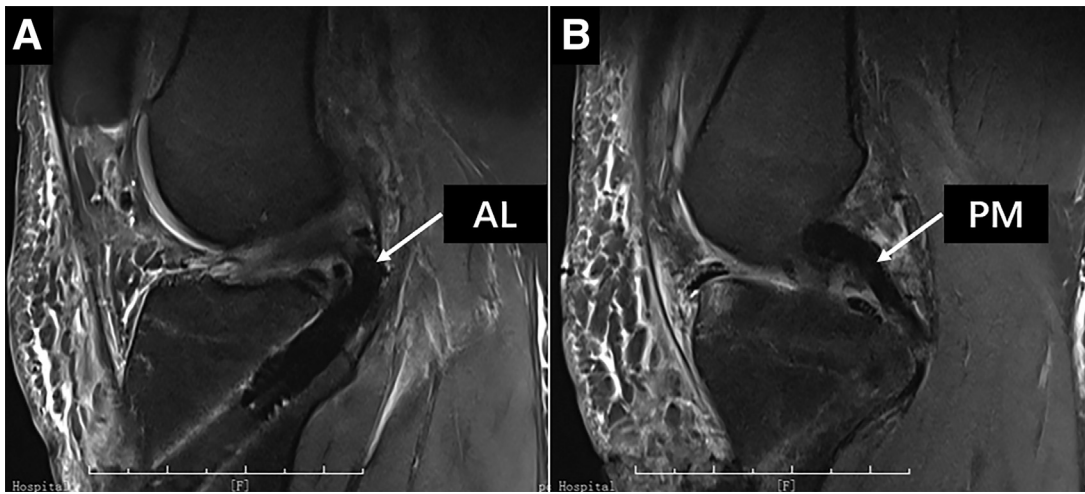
Postoperative sagittal view magnetic resonance images indicating the curving anterolateral-bundle graft (A) and the straight posteromedial-bundle graft (B) (right knee).
